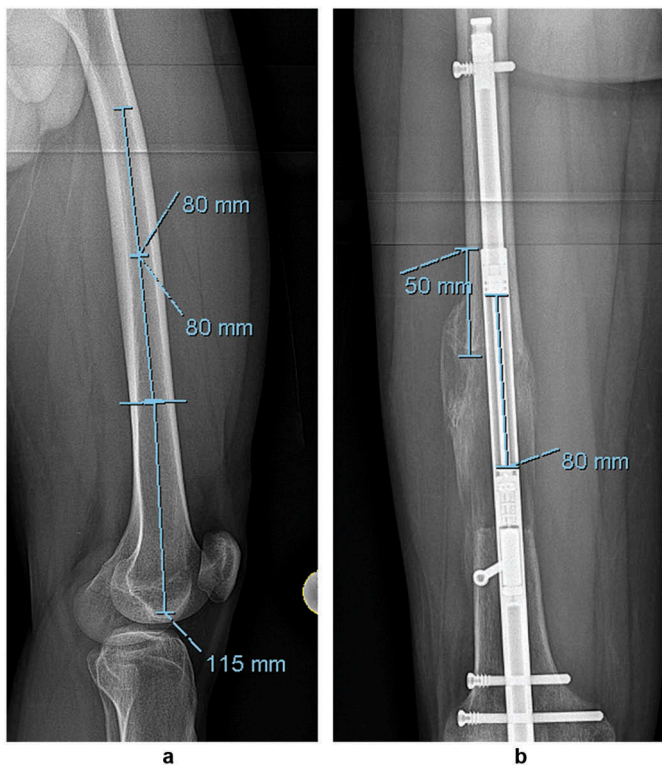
(a) This lateral radiograph shows the pre operative planning for an 80mm lengthening. In order to keep 50mm of the thick portion of the nail in the proximal fragment one needs to add 80mm (50mm + 30mm tip of the nail) to the 80mm planned distraction = 160mm. For the proposed osteotomy site, the distal length of the nail will be 115mm. The shortest nail length (SNL) is $160 + 115 = 275$ mm. This is also the longest nail length as the proximal tip will scrape the anterior femoral bow. The SNL could be lowered by moving the osteotomy site distally. (b) The 275mm nail was used and at end distraction of 80mm there was 50mm of the thick portion of the nail remaining in the proximal fragment. We believe this is important for nail integrity (prevention of fracture) and maintaining alignment.
